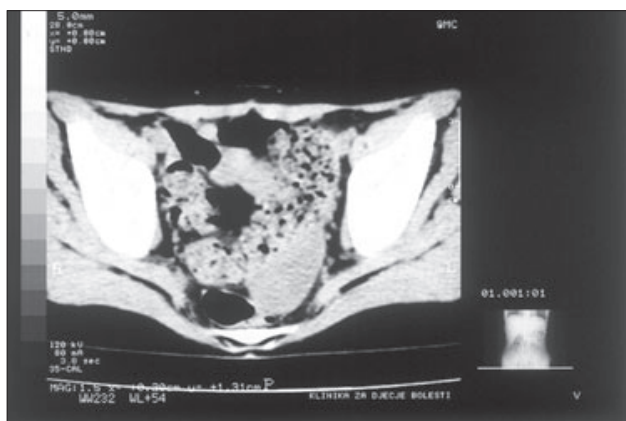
CT scan after 2 PEI preoperative chemotherapy.
